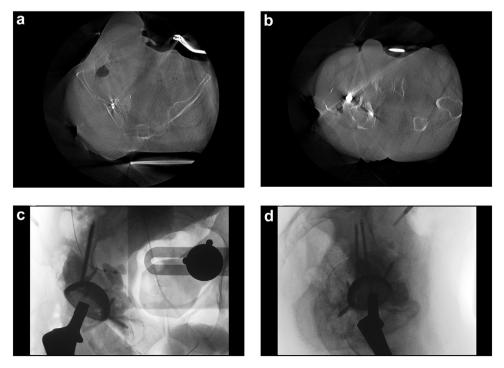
Intraoperative computed tomography imaging shows the placement of screws in the posterior ilium (a) and the ischium (b). Screw placement was confirmed via intraoperative antero-posterior (AP) (c) and lateral (d) fluoroscopic images as well.
